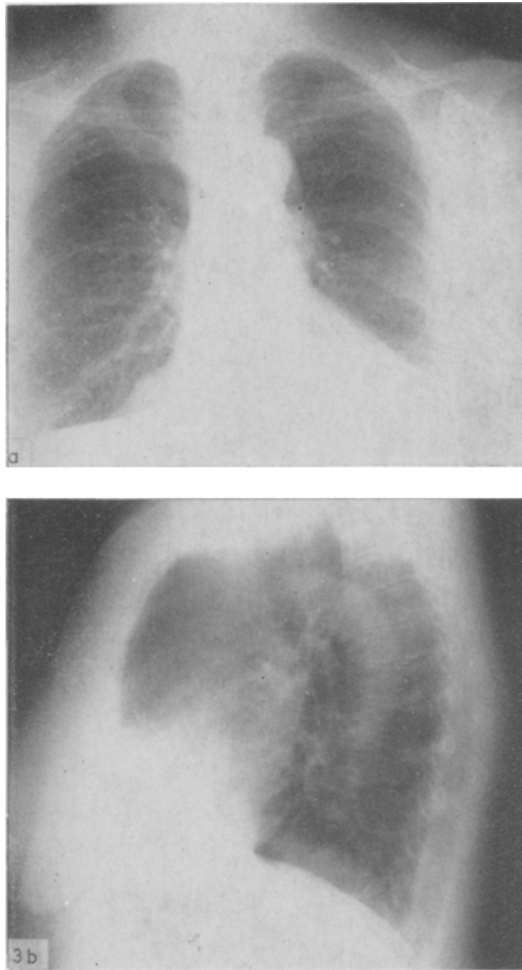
Case 3*: Actual chest X-ray, 11 years after tumour nephrectomy: no evidence of pulmonary metastases
